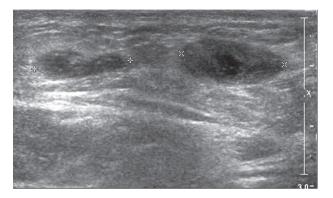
Trunk ultrasonography of abdomen demonstrating periumbilical heterogeneous hypoechoic tubular structure.
